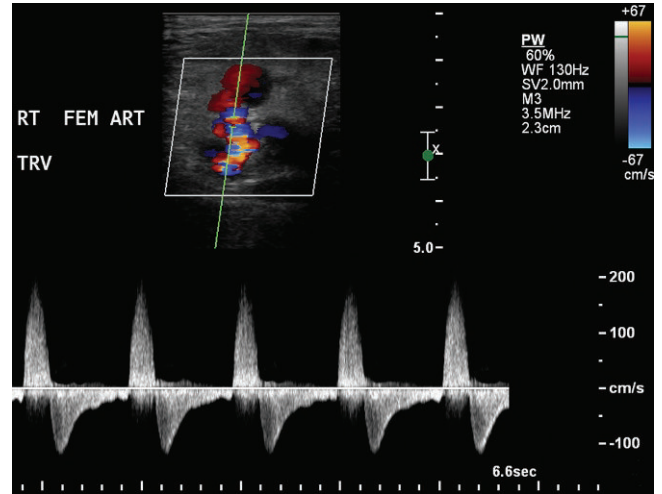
Spectral Doppler of the neck of the pseudoaneurysm demonstrates the typical to and fro waveform. Flow goes into the pseudoaneurysm during systole, and the pressure in the pseudoaneurysm rises and flow exits the pseudoaneurysm during diastole when the pressure in the native vessel is lower.
